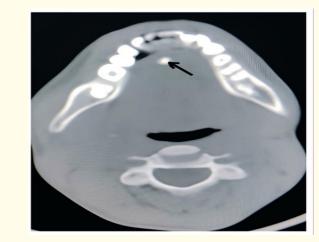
CT image showing distally situated, smaller sialolith in right Wharton's duct.
